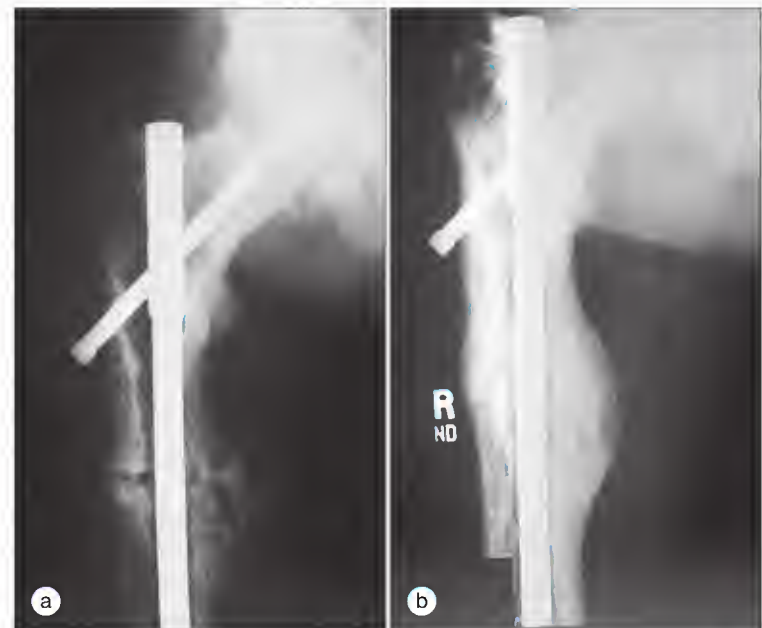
Lateral radiographs of the right femur before (a) and after (b) bisphosphonate therapy. (a) Postoperative lytic lesions are seen in the pagetic bone around the rod placed to stabilize the fracture site. (b) Note the radiographic evidence of healing after therapy with alendronate.
